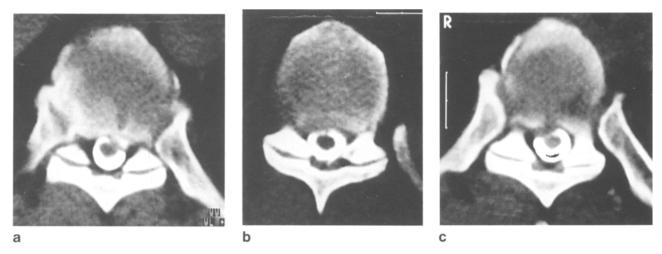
Postmyelographic CT showing the herniated thoracic discs at T7-8 (a), T8-9 (b), and T9-10 (c) levels
